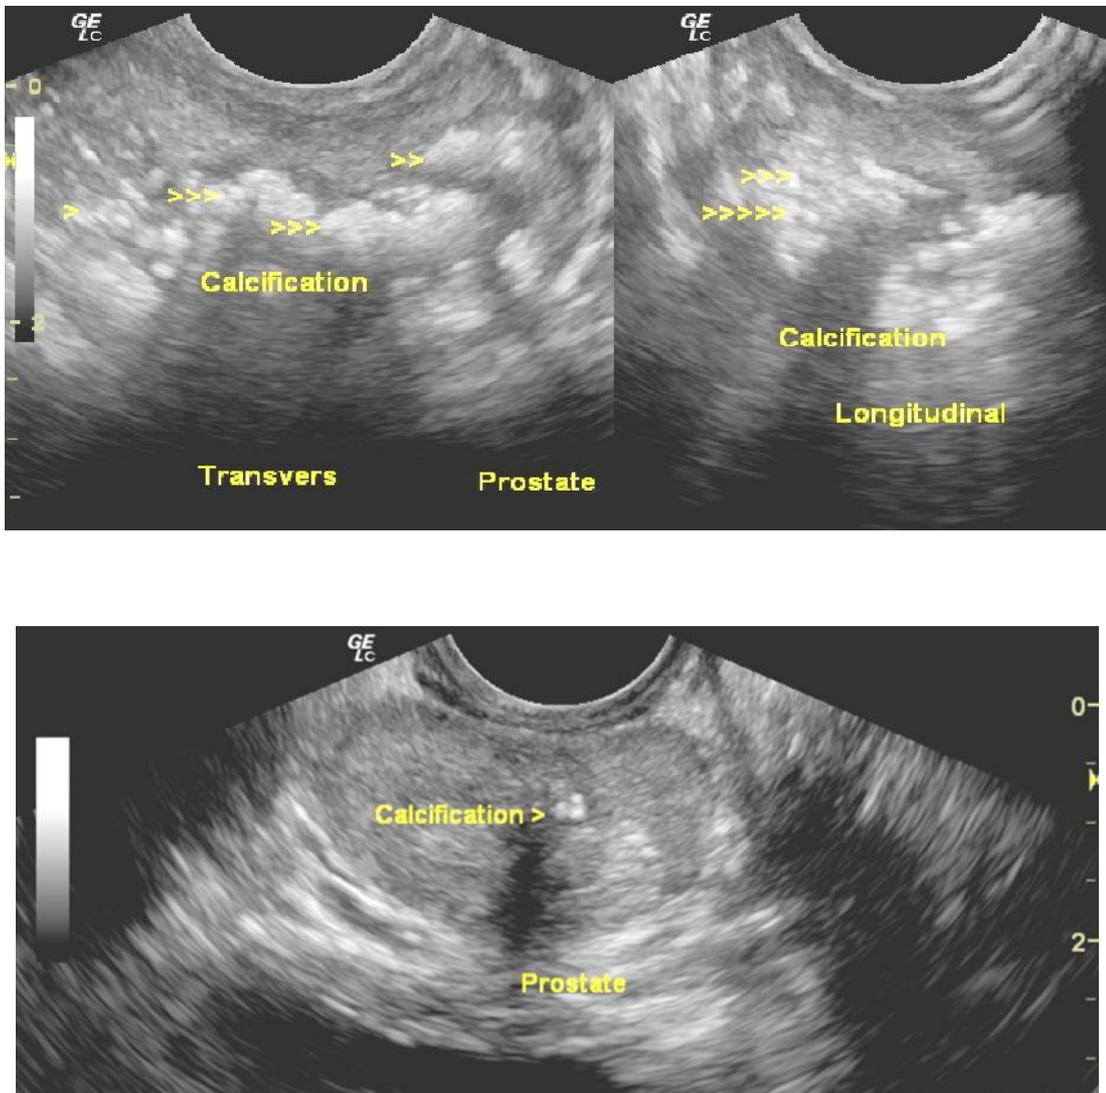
Images of ultrasound scanning of the prostate with calcification in two different subjects.
